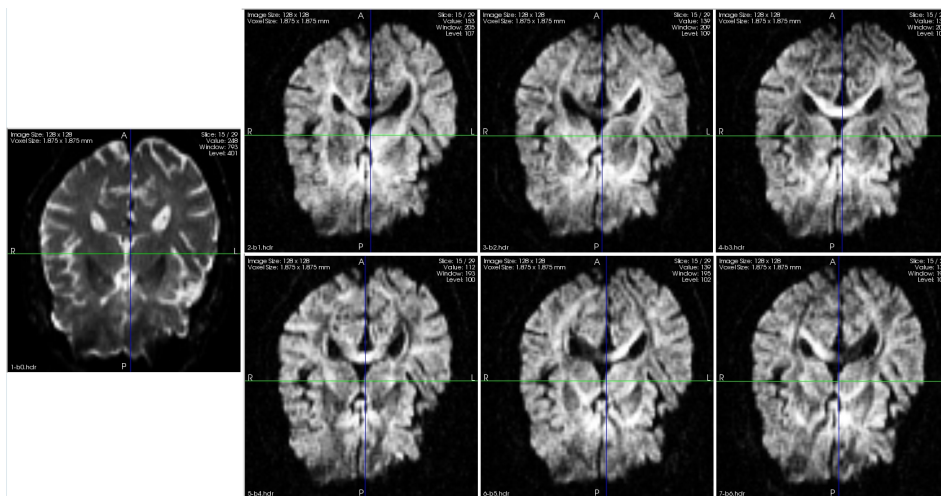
Slices of a DT-MRI acquisition typical of a clinical environment. (Courtesy of Denis Ducreux, MD, Bicêtre Hospital, Paris.) Image dimensions: $128 \times 128 \times 30$, spatial resolution: $1.8 \times 1.8 \times 4mm$. The dataset is made of one baseline image (the most-left image) plus 6 diffusion-weighted images (using Basser’s sequence [Basser 1994a] was used).
